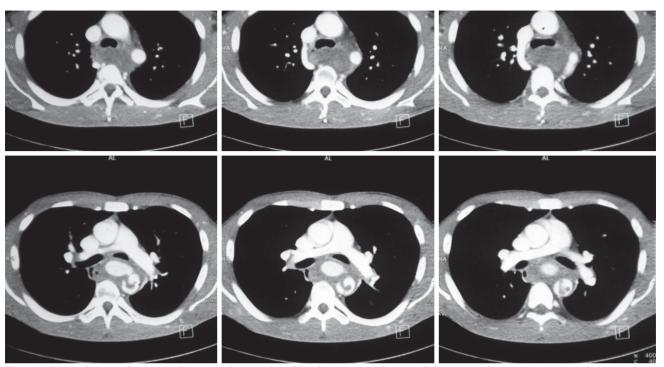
Computed tomography angiography images of aortoesophageal fistula, coarctation of aorta, and abscess around aorta, compressing esophagus.
